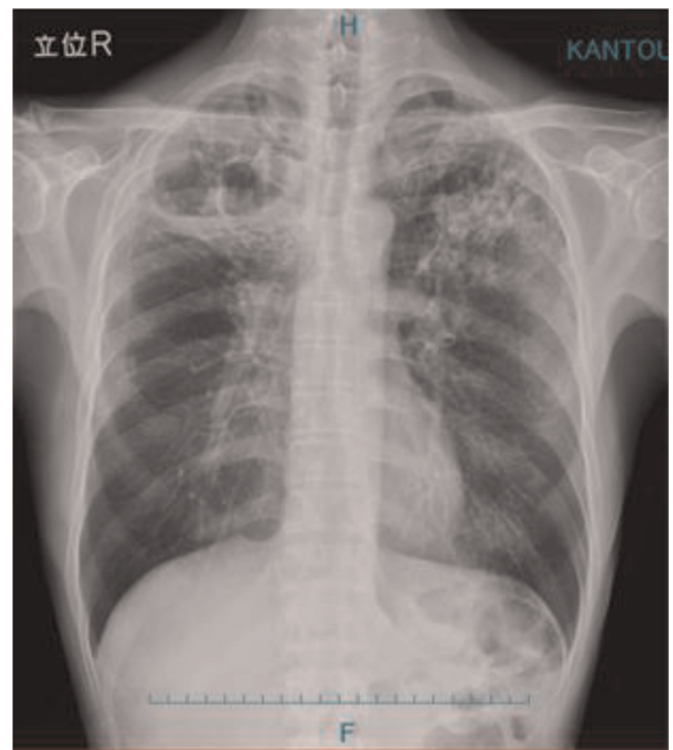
The thoracic plain radiograph of case 2.
